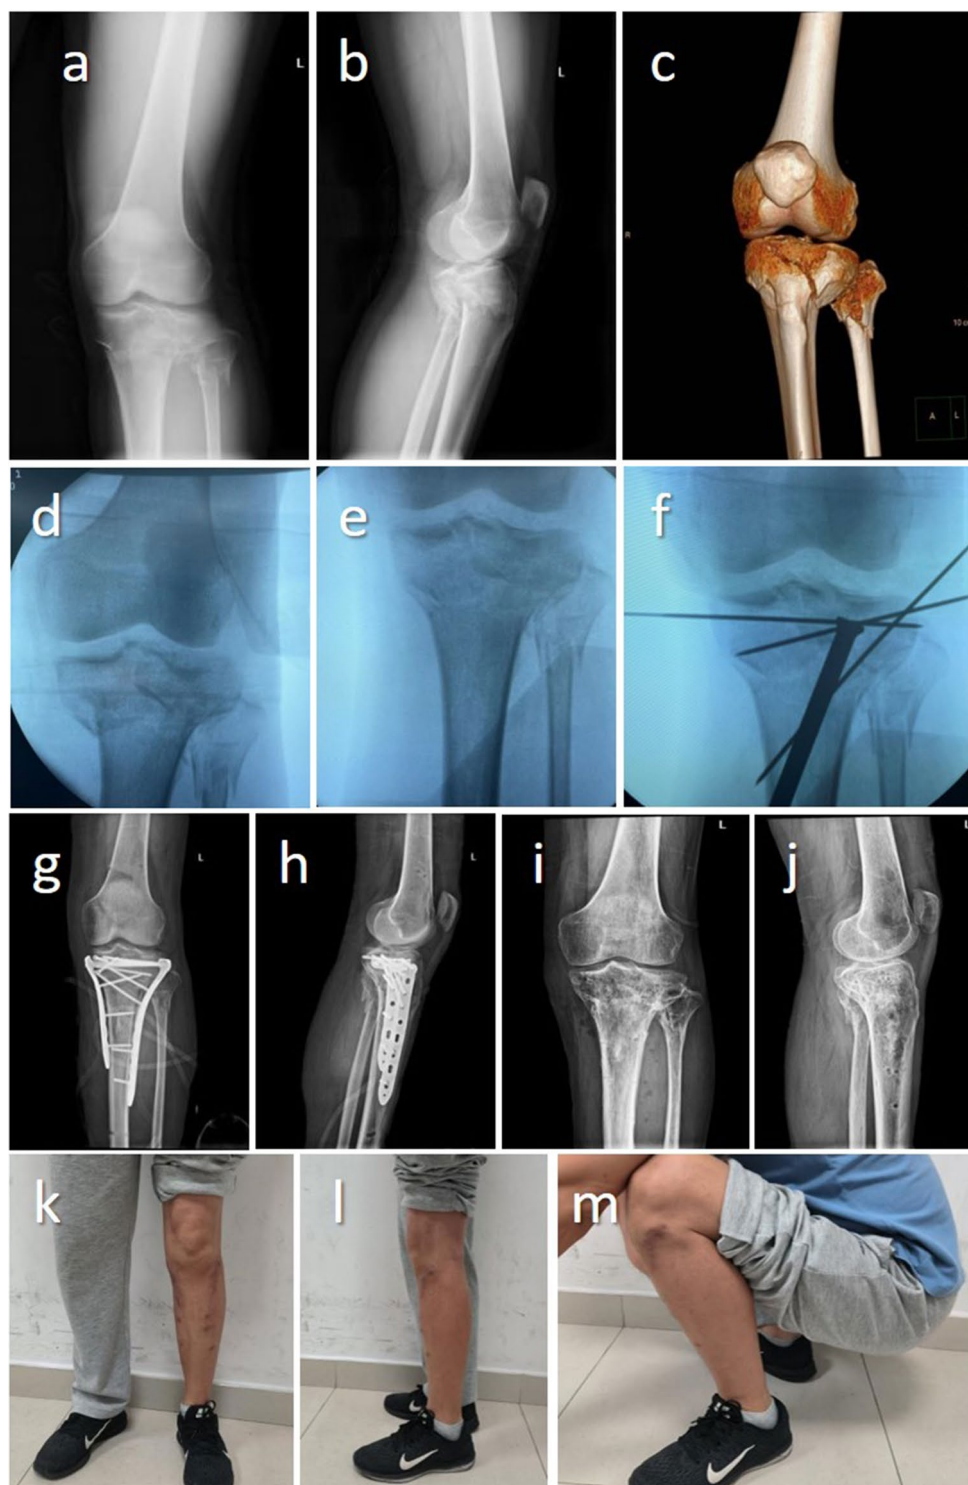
A middle-aged male with Type AO/OTA 41C2 tibial plateau fractures. Preoperative X-ray and three-dimensional CT reconstruction show a AO/OTA 41C2 TPF. (a–c) Preoperative X-rays and CT images. (d) The fractured end of the tibial plateau before installing the traction fixator was altered by its insertion. (e) The vertical shortening deformity of the fracture was corrected after traction repositioning using a temporary bi-frame fixator. (f) The collapsed articular surface was repositioned by applying the MIPPO technique with a nail bar and was temporarily fixed with Stienen pins. (g–j) Postoperative X-ray films and internal fixation removal. (k–m) Postoperative functional recovery
